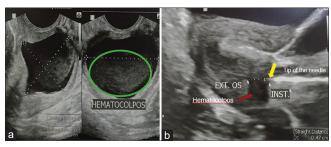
Ultrasound-Guided Excision of Transverse Vaginal Septum.
